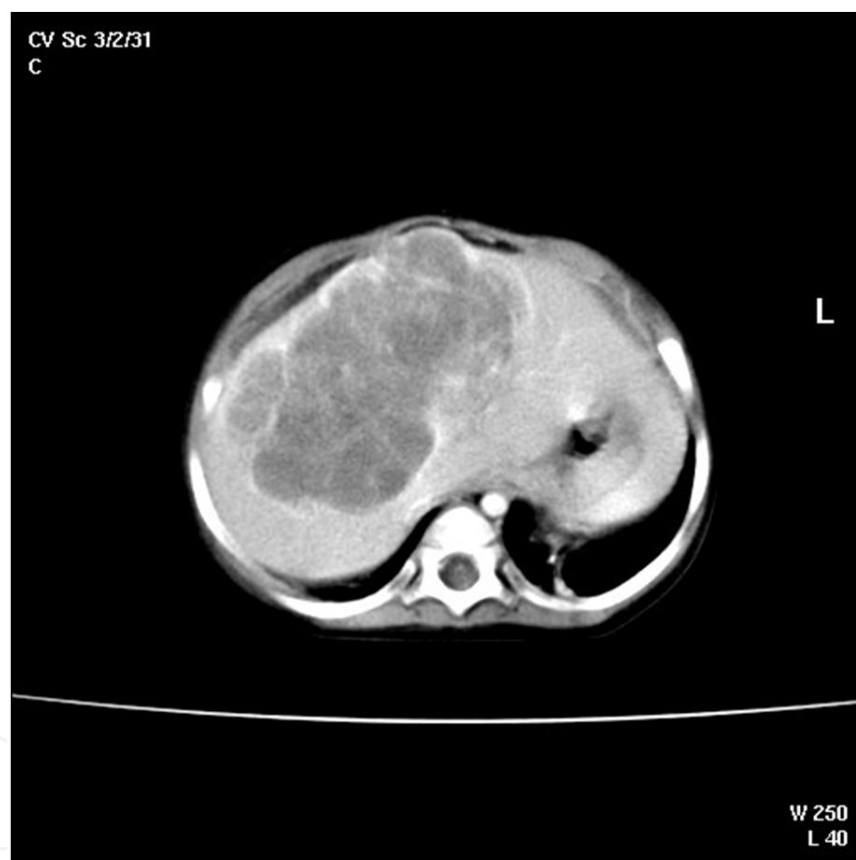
CT scan of an infant with a large central hepatoblastoma.
